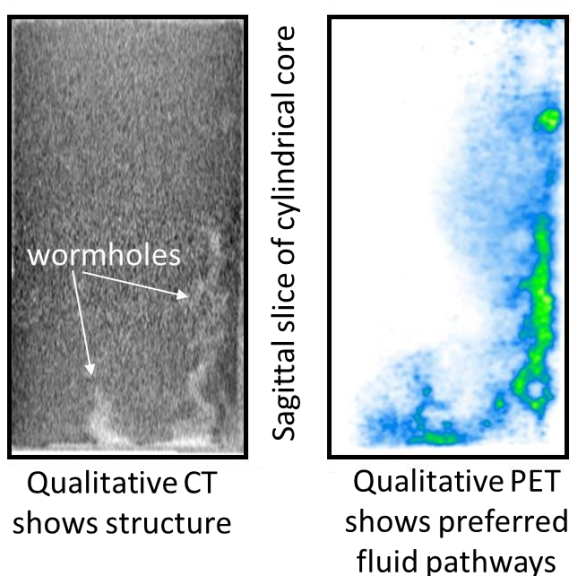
Dissolution of carbonate during CO₂ or carbonated water injection is often visualized using CT, but PET imaging may be an important contribution. While CT (left) portrays structural changes during dissolution, PET determine dynamic changes in the preferred flow paths within the core.
